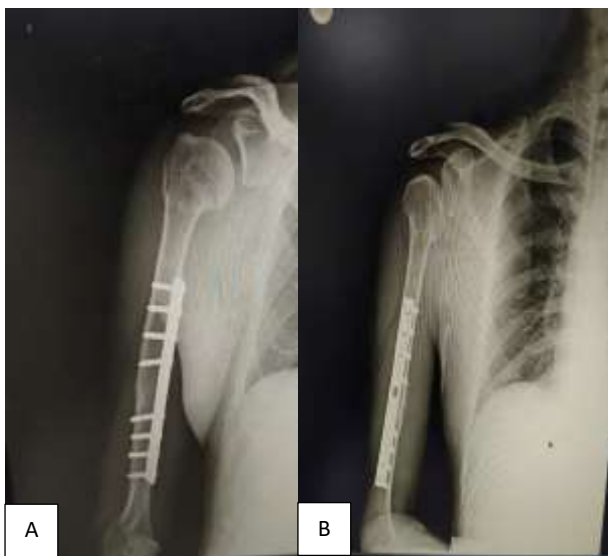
(A and B): Preoperative x-rays.
